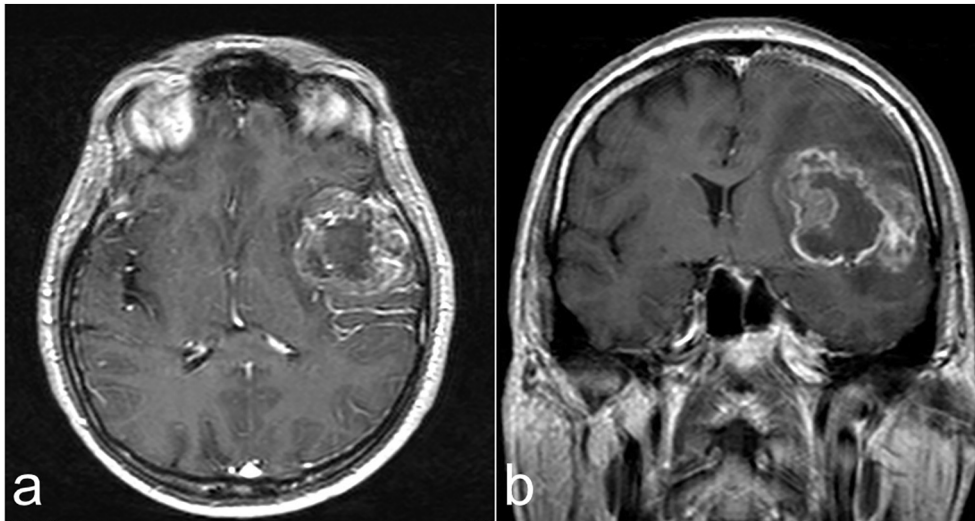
Preoperative contrast-enhanced MRI. Axial (a) and coronal (b) images, compatible with high grade glioma.
